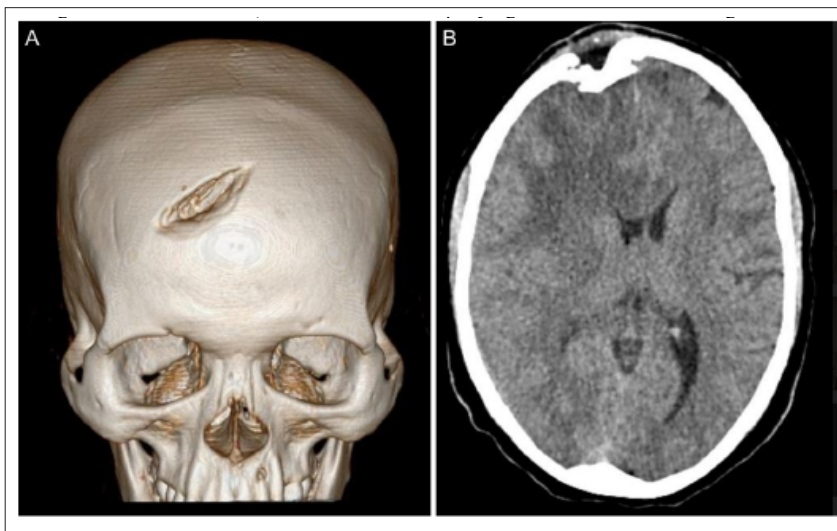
A: Three-dimensional reconstruction of a computed tomography brain image demonstrating the depressed skull fracture in the right frontal bone. B: Axial view of accompanying soft-tissue window images.
